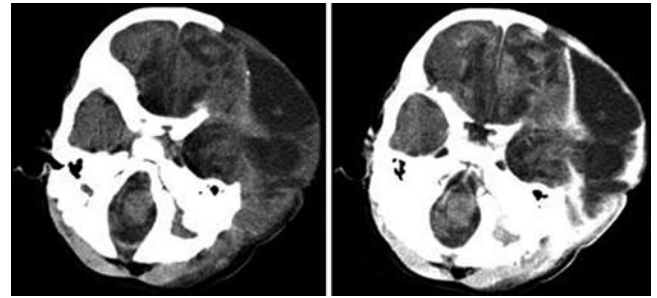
Case 7. Postoperative CT scans. Left: Noncontrast head CT scan obtained in a 24-month-old boy 3 weeks after a left decompressive craniectomy showing a large extraaxial fluid collection. Right: Head CT scan with contrast administration in the same patient showing contrast enhancement in the extraaxial fluid, indicating infection.
